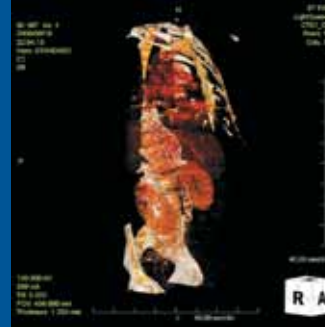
Follow-up CTA with 3D reconstructions at 6 weeks shows the stent graft to be excluded with filling of the celiac artery through the iCast stent without evidence of an endoleak.
